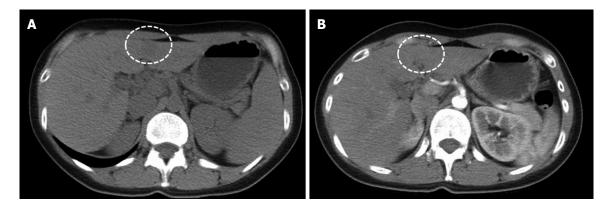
Computed tomography of lymphoepithelioma-like cholangiocarcinoma (dash circle). A: Noncontrast CT showed a small hypodense nodule (38 HU) at the lateral segment of liver; B: The tumor nodule depicted enhancement in early arterial phase of contrast enhanced CT (65HU).
